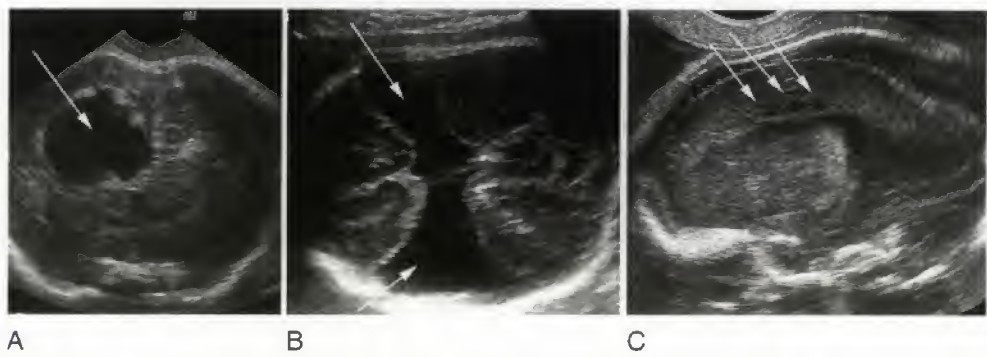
Joubert syndrome. The sonographic findings are limited to the presence of a communication between the fourth ventricle (arrow) and the cisterna magna (A) and an abnormal shape of the fourth ventricle (arrow) (B). C. Postnatally, magnetic resonance imaging demonstrates the absence of the cerebellar vermis between the cerebellar hemispheres (arrows). (Courtesy Philippe Jeanty, Nashville, TN.)
